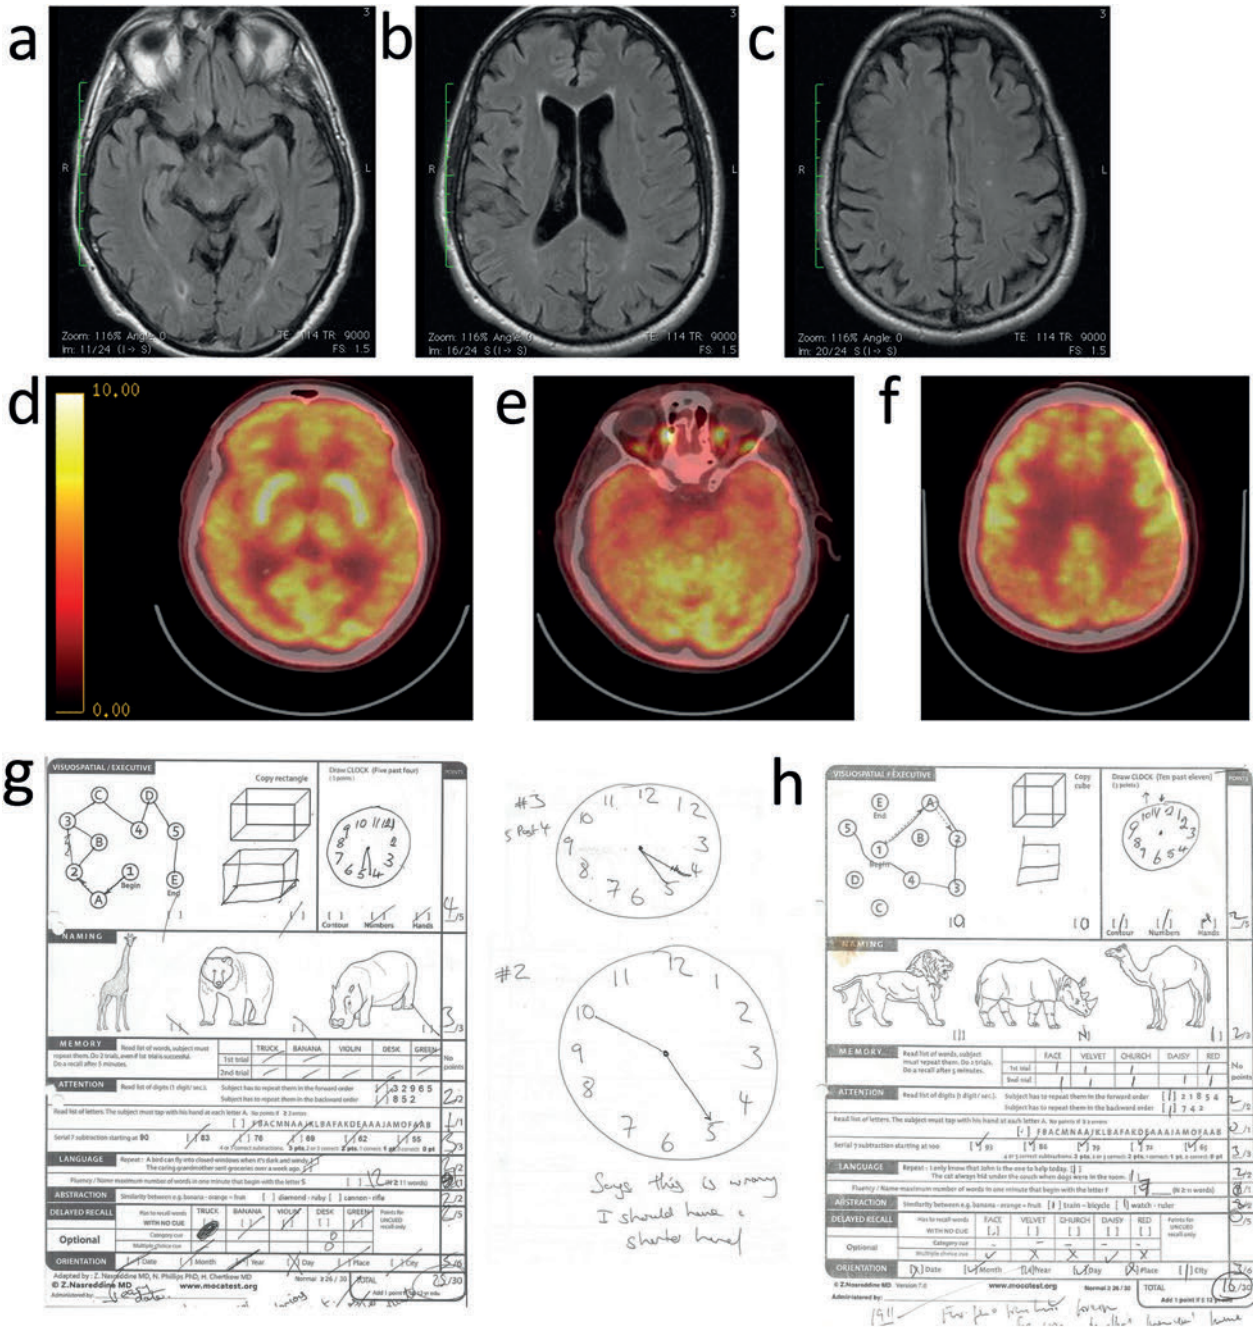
MRI and PET imaging a, b, c: Axial MRI (FLAIR) images through the temporal lobes (a), the lateral ventricles (b) and the centrum semi-ovale (c). The images show mild generalized atrophy without focal lobar, cortical, or subcortical atrophy and normal white matter for his age. d, e, f: Positron emission tomography (PET) using radiolabeled through the caudate (d), the temporal lobes (e), and the centrum semiovale (f) showing generalized cortical hypometabolism. g: Montreal Cognitive Assessment (MOCA) exam 2009 with abnormal hand placement on several attempts at the clock. h: MOCA exam 2011.
